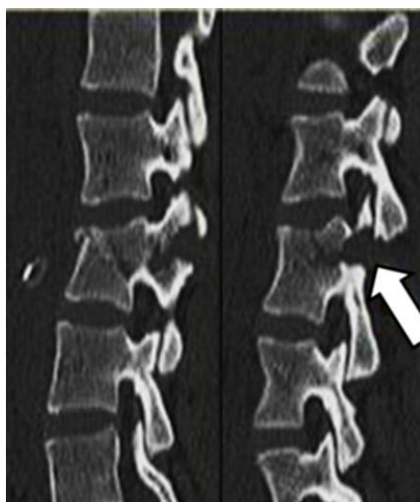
CT image of chance (seat belt) fracture
